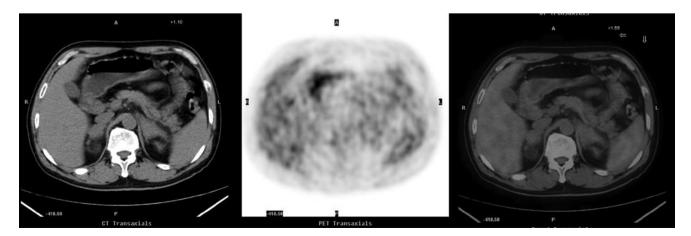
Second <sup>18</sup>F-FDG PET/CT scan after treatment: No high uptake of tracer in bilateral adrenals.
